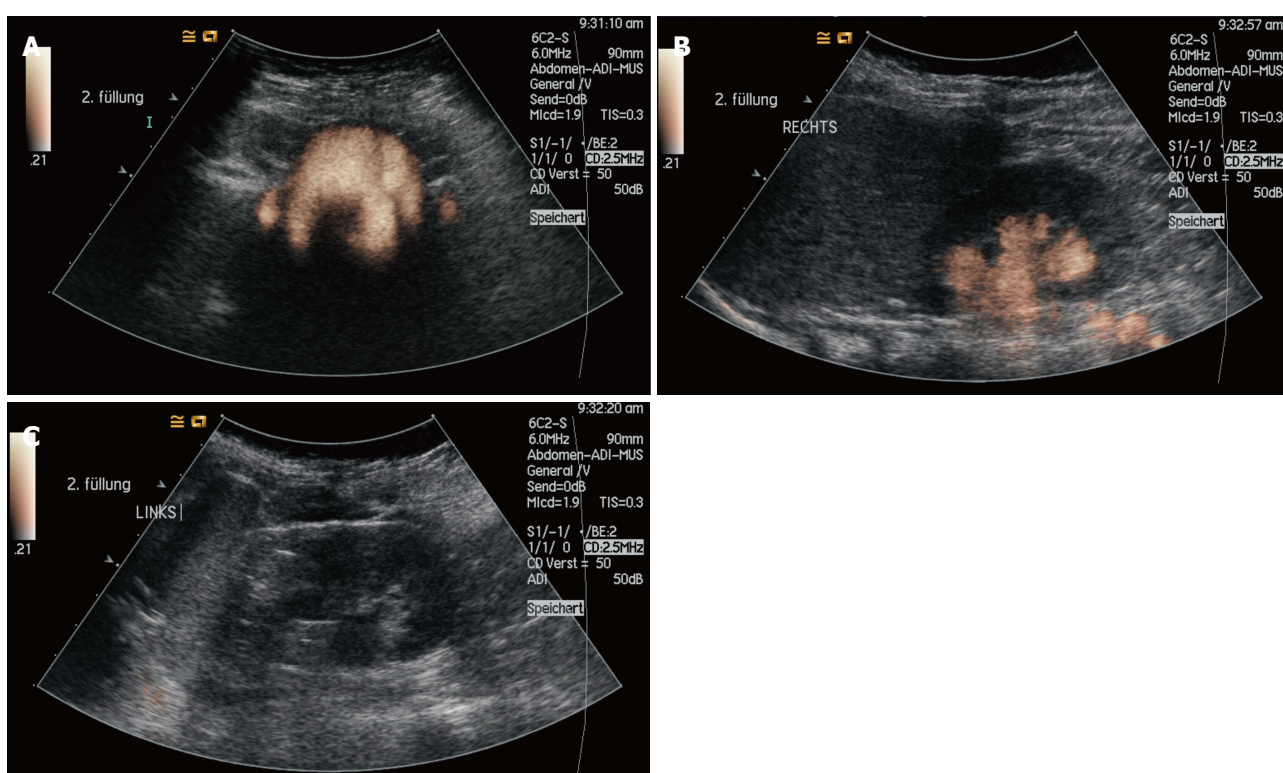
Voiding urosonography of a 6-year-old girl with proven, bilateral vesicoureteral reflux (grade I left and grade III right). The voiding urosonography scan shows the urosonography contrast agent microbubbles in both ureters and in the left renal pelvis (A: Bladder and distal ureters; B: Right kidney and proximal ureter; C: Left kidney).
